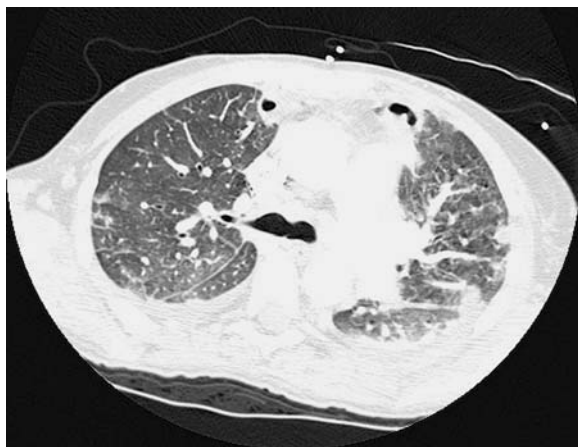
Septic emboli in a 43-year-old woman with endocarditis. Chest CT scan (collimation 16×1.25 mm) shows multiple pleural-based nodules. Note vessel-feeding sign in left lower lobe and cavitary nodules adjacent to heart
